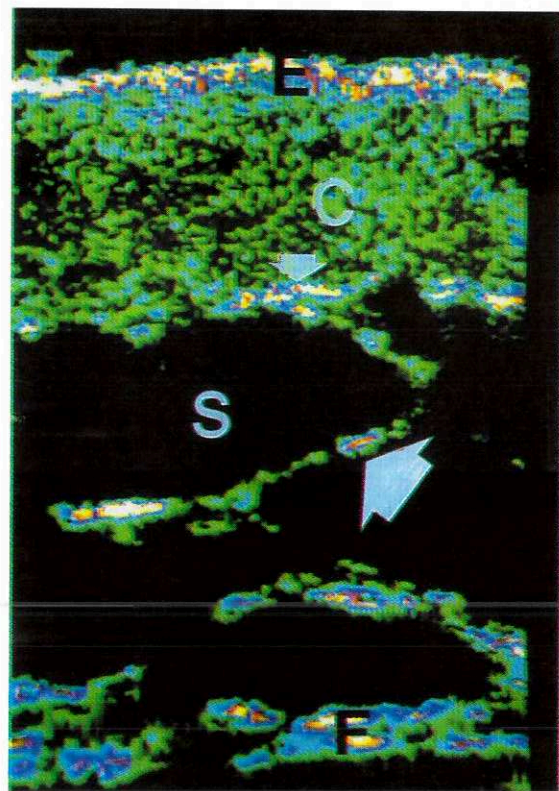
Ultrasound B-scan of a sclerotic plaque in the right groin (Case Study 2) (E: entry echo; C: corium; S: subcutaneous fatty tissue; F: muscle fascia; small white arrow: reflex spots; large white arrow: echorich bands).
